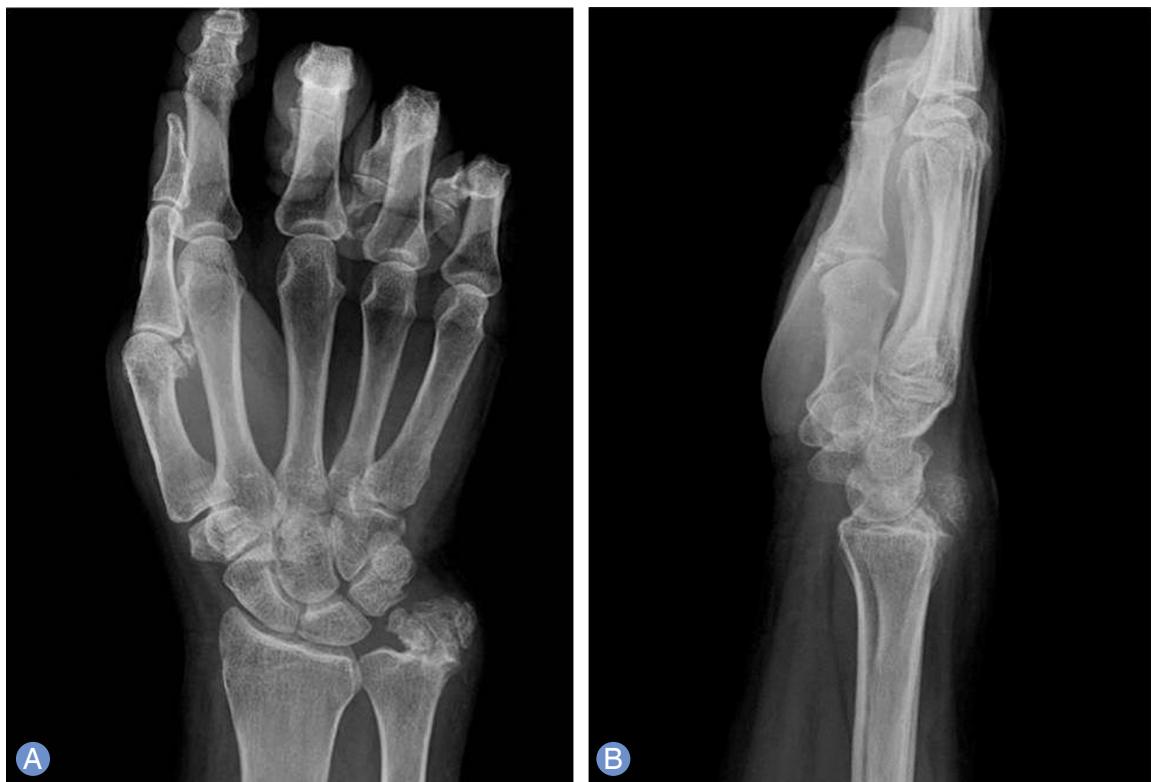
Multiple osseocartilaginous masses can be observed in the ulnocarpal joint on an anteroposterior radiograph (A) and in the dorsal aspect of the wrist on a lateral radiograph (B).
